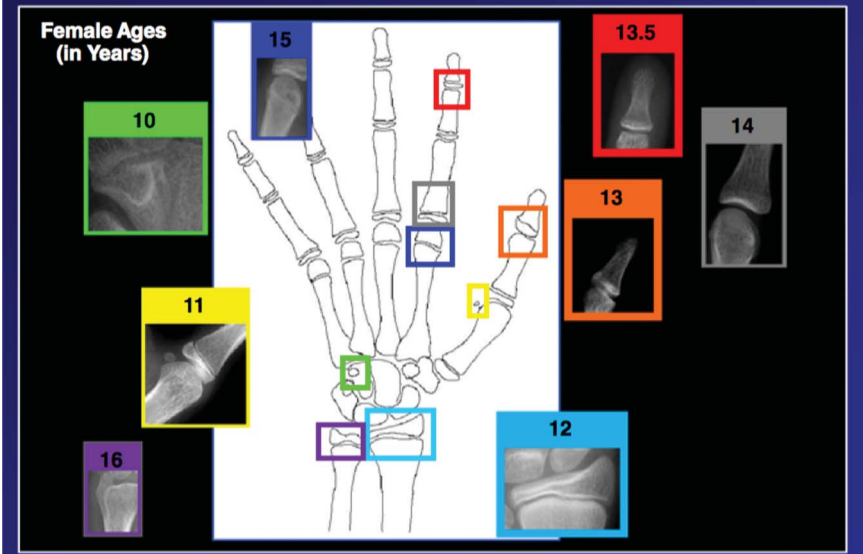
Figure showing shorthand bone age assessment for females. This figure demonstrates a characteristic change in the bone age radiograph at key time points during the female adolescent growth spurt. (Reproduced with permission from Heyworth BE, Osei DA, Fabricant PD, et al: The shorthand bone age assessment: A simpler alternative to current methods. *J Pediatr Orthop* 2013;33:569-574.)
